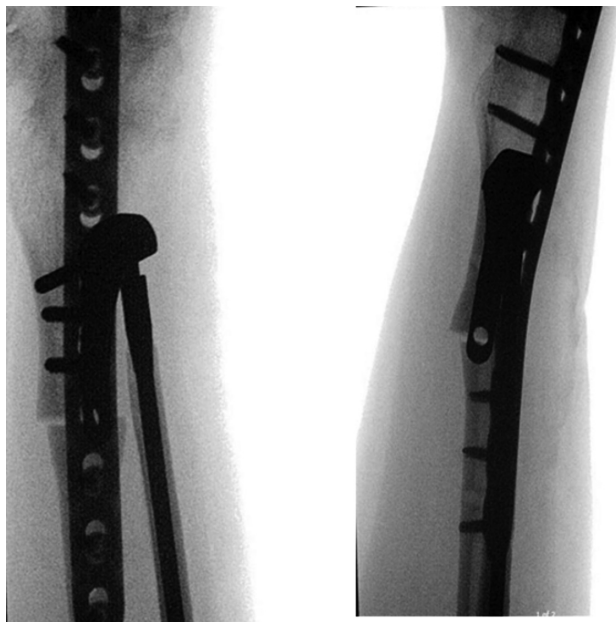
Perioperative anteroposterior and lateral X-rays of Case 2, 16 months after placement of the Aptis implant.
